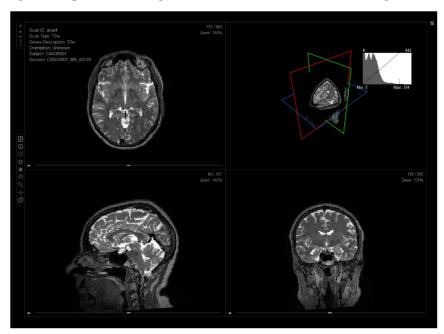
Visualization of 3D MRI Data from NII Files
